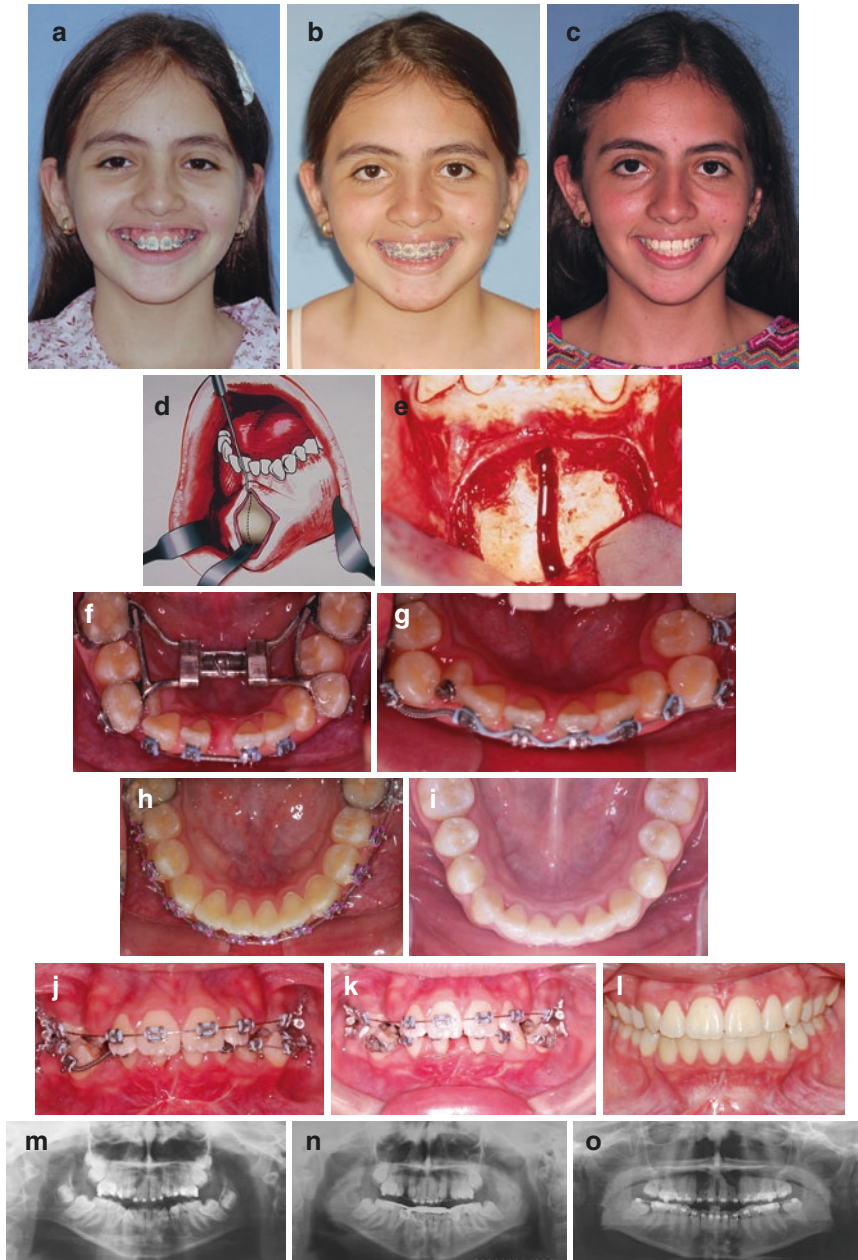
Transverse or horizontal deficiency in a 11-year-old female. Treatment plan included mandibular osteotomy for distraction expansion. Total orthodontic surgical treatment time was 12 months. (a) Preoperative. (b) Postoperative frontal facial views are shown (c) 4 years follow up. (d–e) Vertical osteotomy of mandible for mandibular widening. (f) Mandibular occlusal view showing transverse deficiency and during activation. (g) Orthodontics alignment. (h) Mandibular view during orthodontic therapy (i) Posttreatment mandibular occlusal view with dental restoration. (j) Pretreatment intraoral frontal view. (k) Intraoral frontal view during activation. (l) Posttreatment intraoral view. (m) Pretreatment panoramic radiograph. (n) Posttreatment panoramic radiograph. (o) Panoramic radiograph 7 years follow-up
